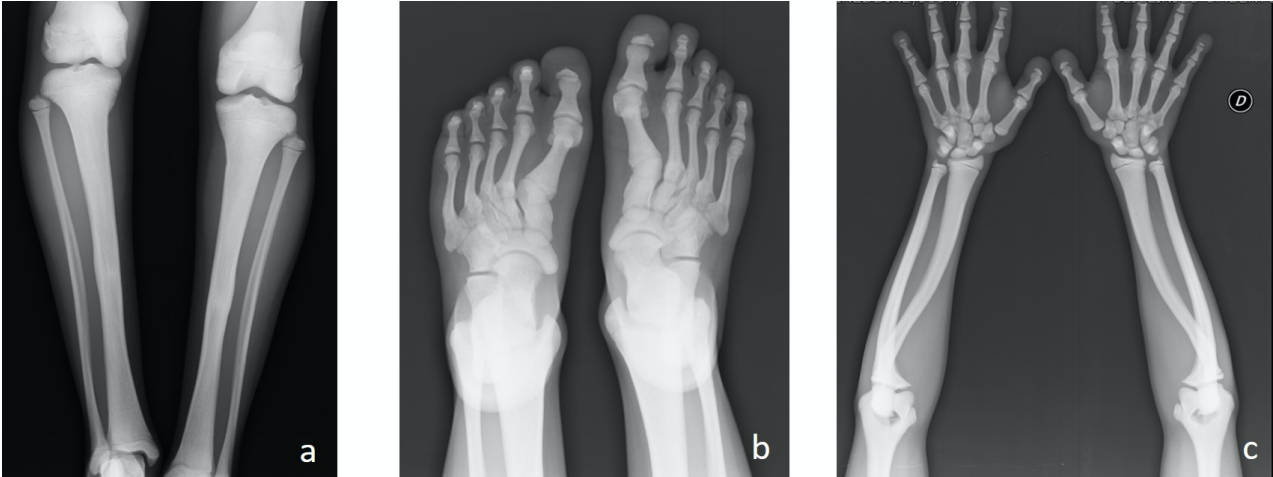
a) anteroposterior view X-ray of bilateral tibia and fibula showing signs of previous fractures; b) dorsoplantar view X-ray of left and right foot with hallux valgus and partial bone resorption of distal phalanges; c) X-ray of right and left forearm and hand showing deformity of the radius and partial bone resorption of distal phalanges.
